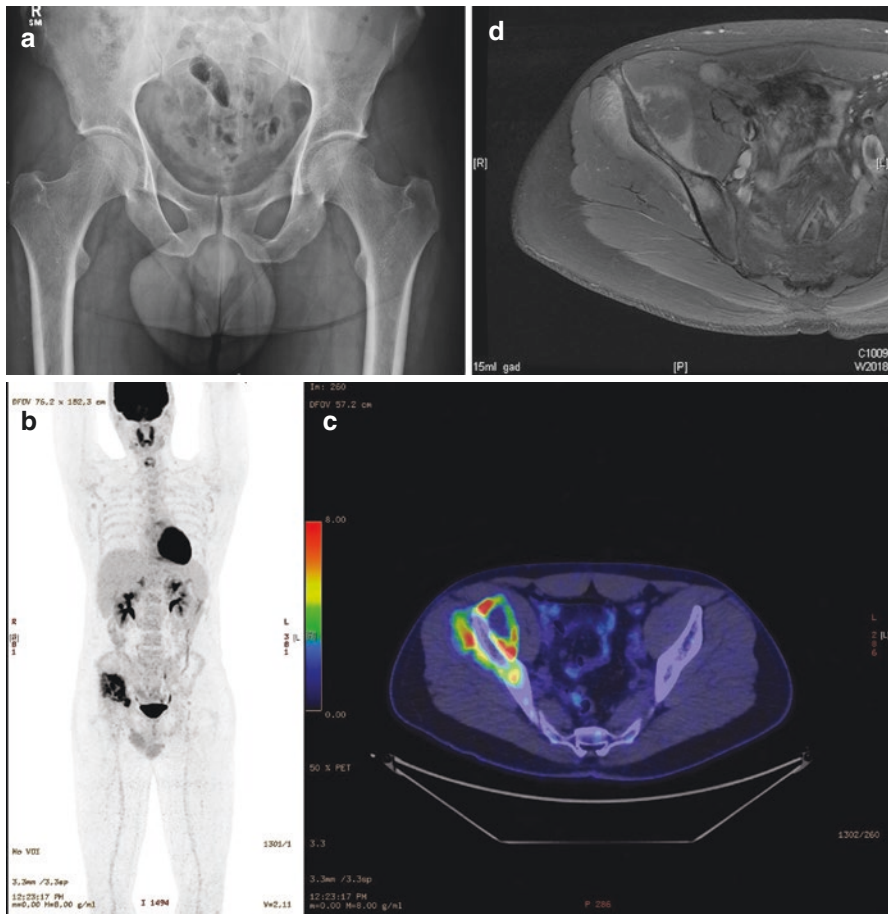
(a) A 29-year-old male presents with right-sided pelvic and hip pain. X-ray initially reported as normal but demonstrates on review very subtle sclerosis involving the right iliac wing. (b) F18-FDG PET/CT whole-body MIP image demonstrates irregularly increased uptake involving the right hemi-pelvis and acetabulum. (c) F18-FDG axial fused images showing marginal activity within a soft tissue mass medial to the bony ileum consistent with viable active tumour and central photopaenia indicating tissue necrosis. Further viable tumour lies adjacent and lateral to the ileum. CT-guided biopsy targeting the areas of tracer uptake showed grade 3 chondrosarcoma. (d) Contrast-enhanced T1 MRI demonstrates areas of enhancement directly correspond to the areas of F18-FDG activity
